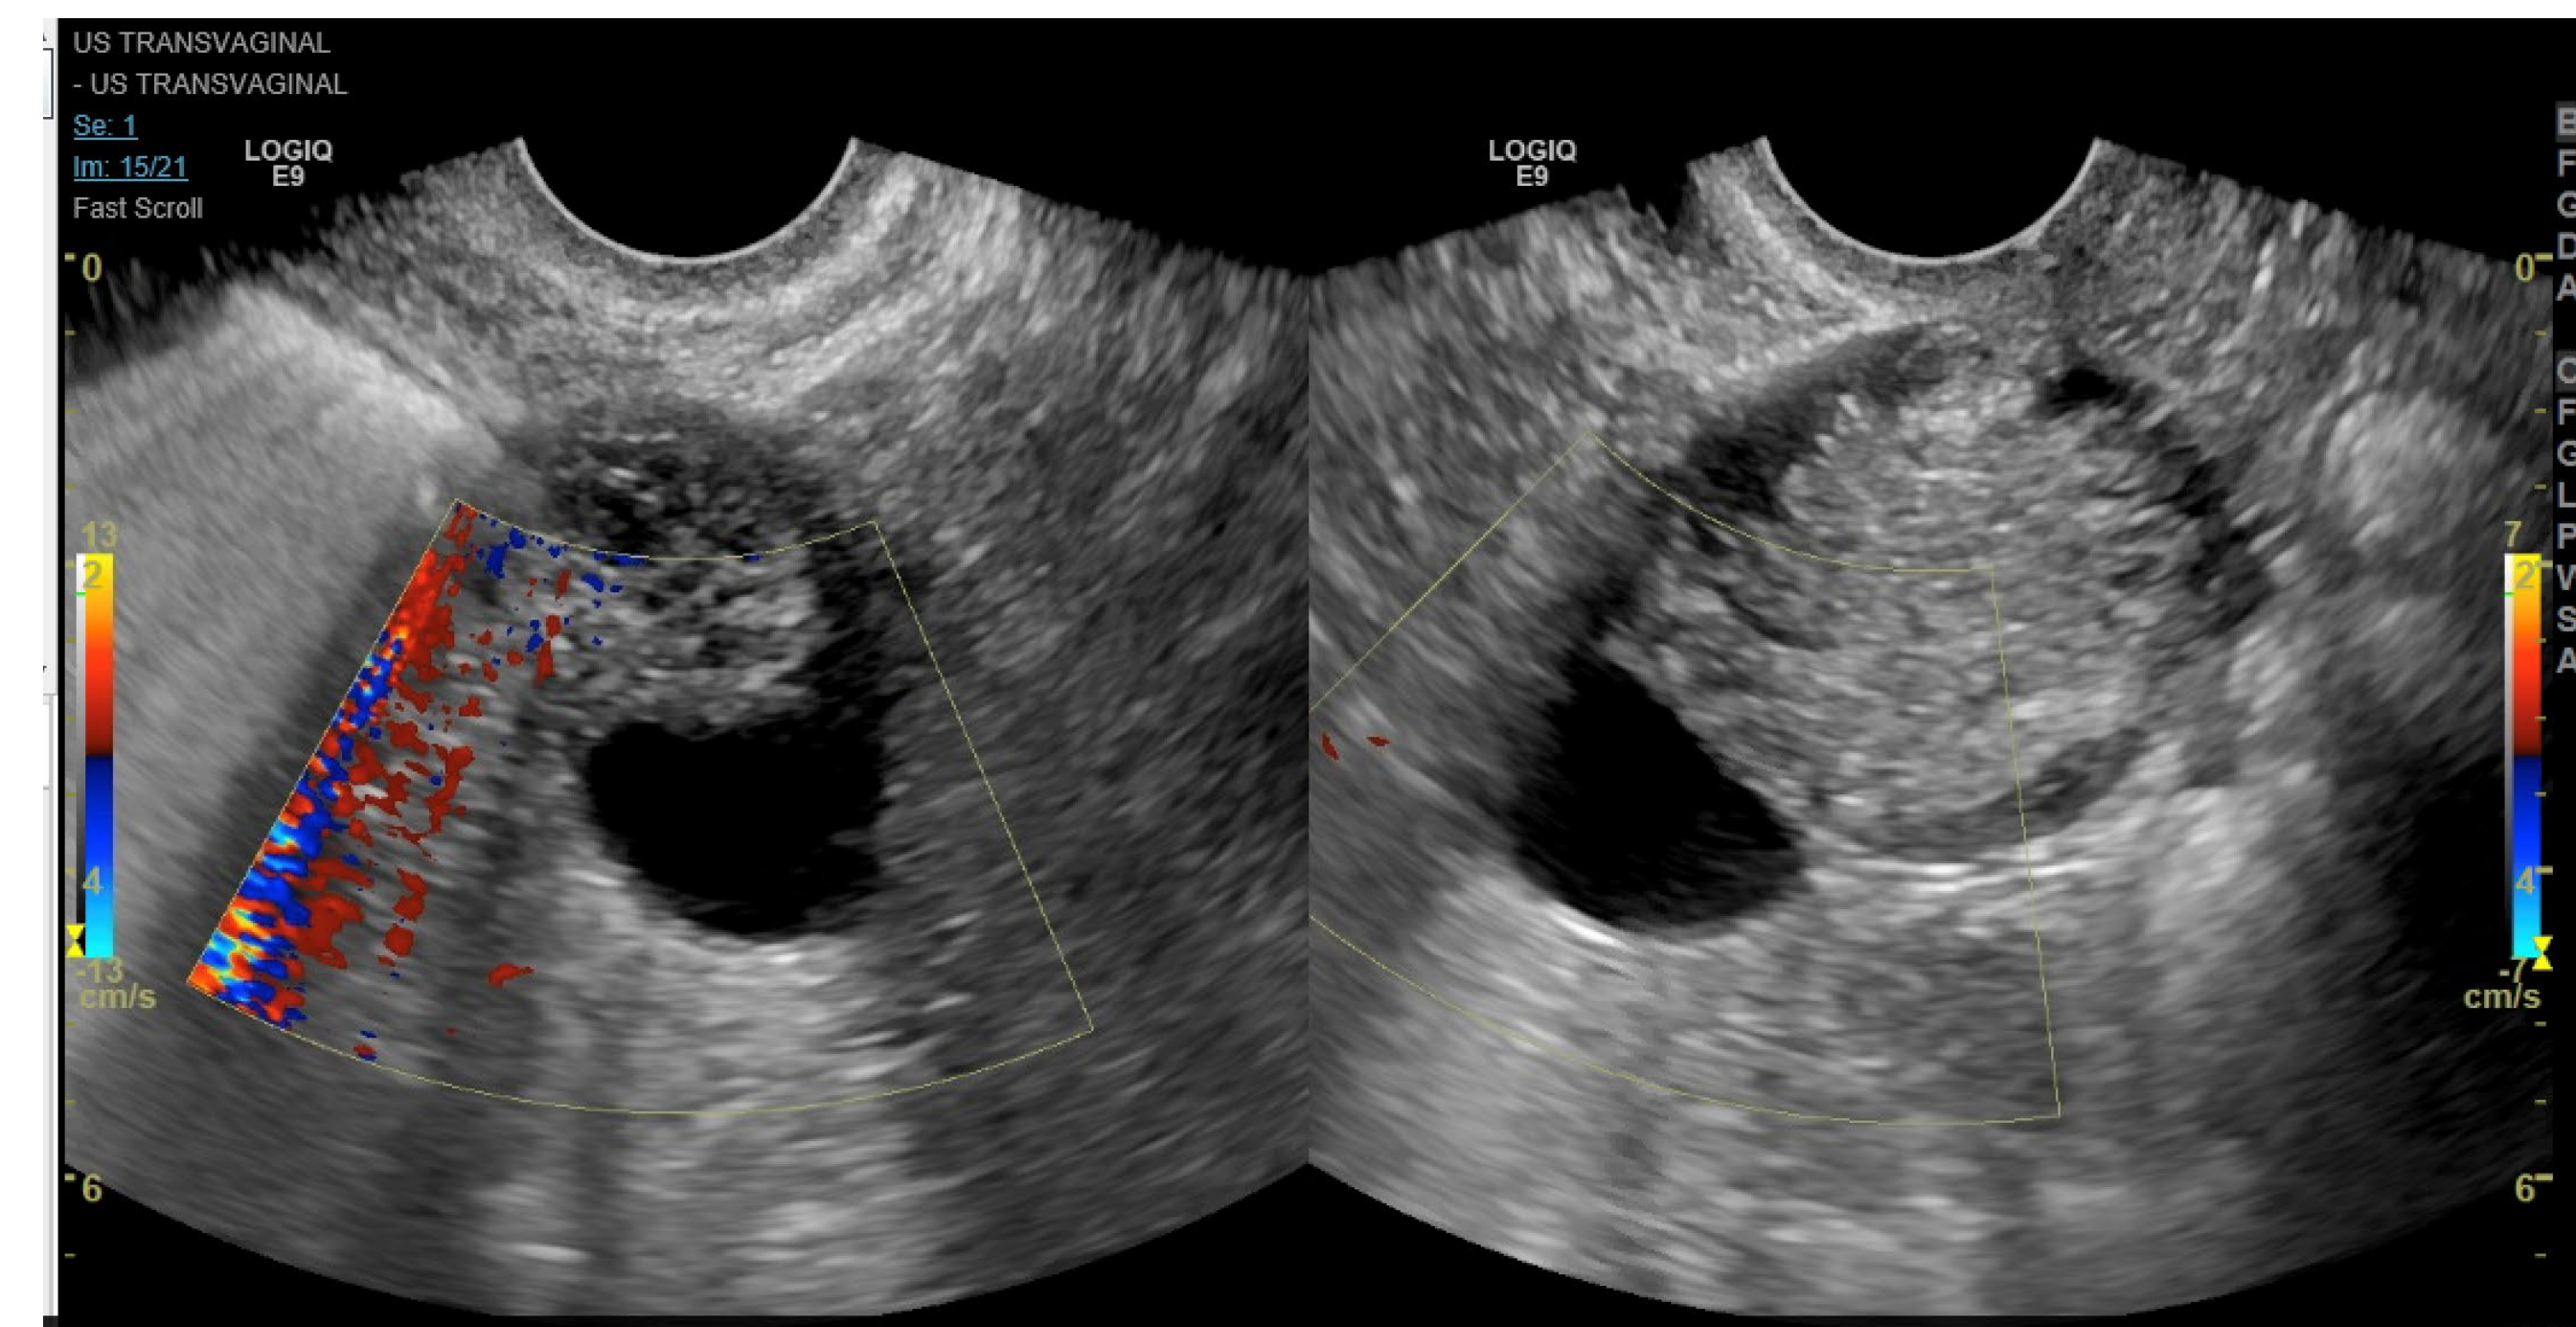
Transvaginal ultrasonography of left ovary with ovarian cyst
